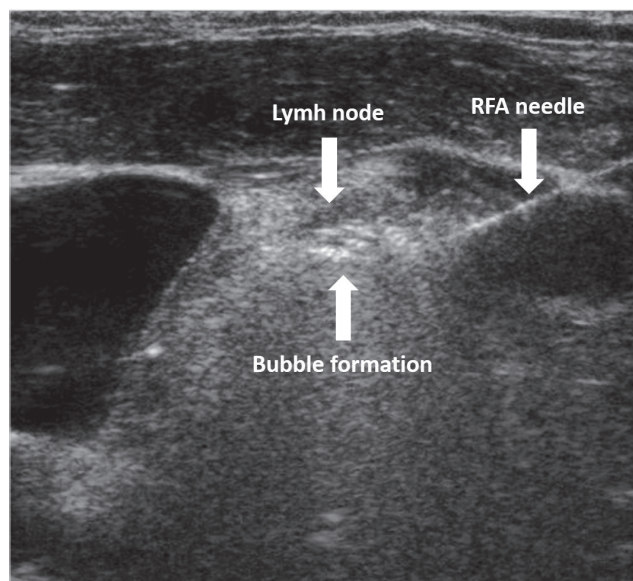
Ultrasonography image showing the complete ablation of the lymph node.
